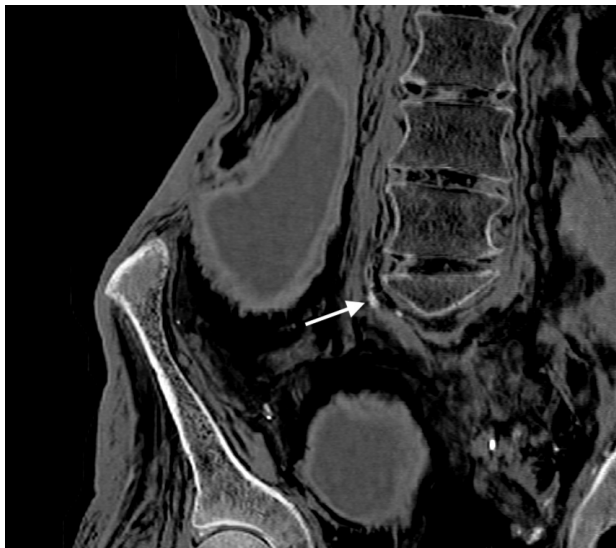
Coronal CT reconstruction showing calcifications in the right iliac artery (arrow).
